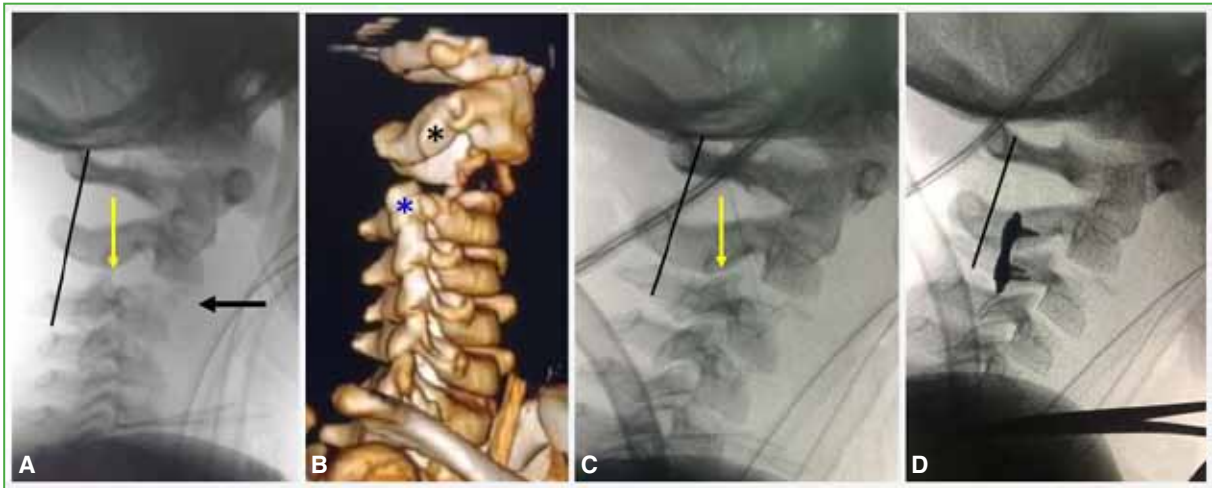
Four-year-old child seated on his mother's lap in the front passenger seat of a car with a seat belt fastened. The car was involved in a frontal collision, with airbag deployment impacting the child. The child presented with Frankel A neurological status on admission, with a metameric injury at the C3 level, diaphragmatic paralysis, hemopneumothorax, and elevated intracranial pressure (eICP). Lateral images of the cervical spine. A. Cervical spine radiograph: C2-C3 dislocation, with facet denudation (yellow arrow) and epiphysiolysis of the base of the axis with a small Thurstand-Holland fragment (Salter-Harris II). SL is not sensitive enough to detect this severe instability. B. 3D CT: Unlinking of the facets of C2 (black asterisk) and C3 (blue asterisk). C. Intraoperative radiograph: reduction showing an adequate facet relationship (yellow arrow). D. Posterior facet osteosynthesis with small fragment material.
